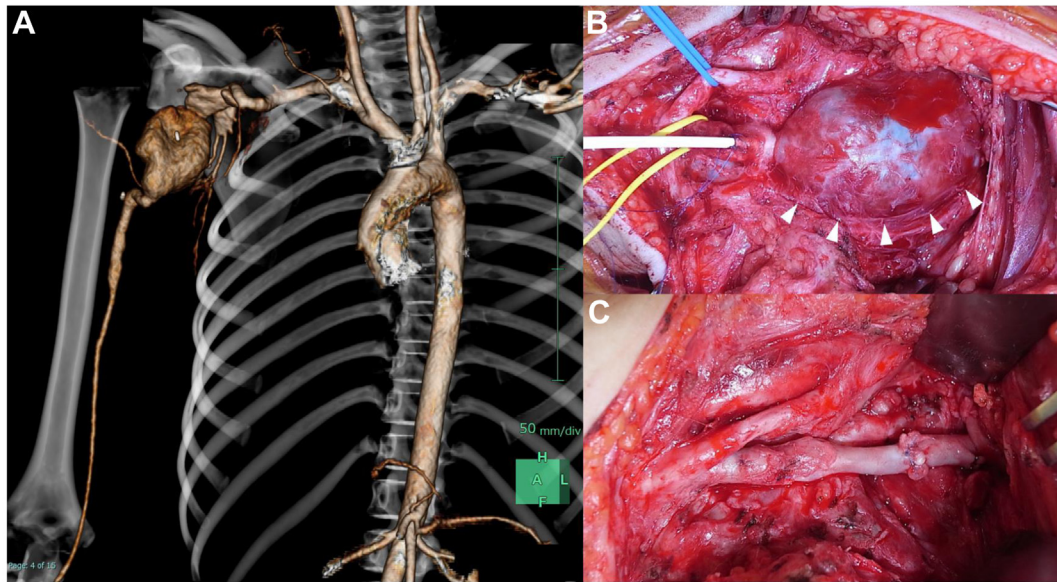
A, Three-dimensional reconstruction of follow-up computed tomography angiogram 4.5 years after initial surgery showing a multifocal 45-mm right axillary artery aneurysm (AxAA). B, The ventral aspect of the AxAA was exposed (*arrowheads*), and a sheath was inserted from the artery distal to the aneurysm. C, Aneurysmectomy and reconstruction with an end-to-end anastomosis of the proximal axillary artery and saphenous vein graft used in the initial surgery.
